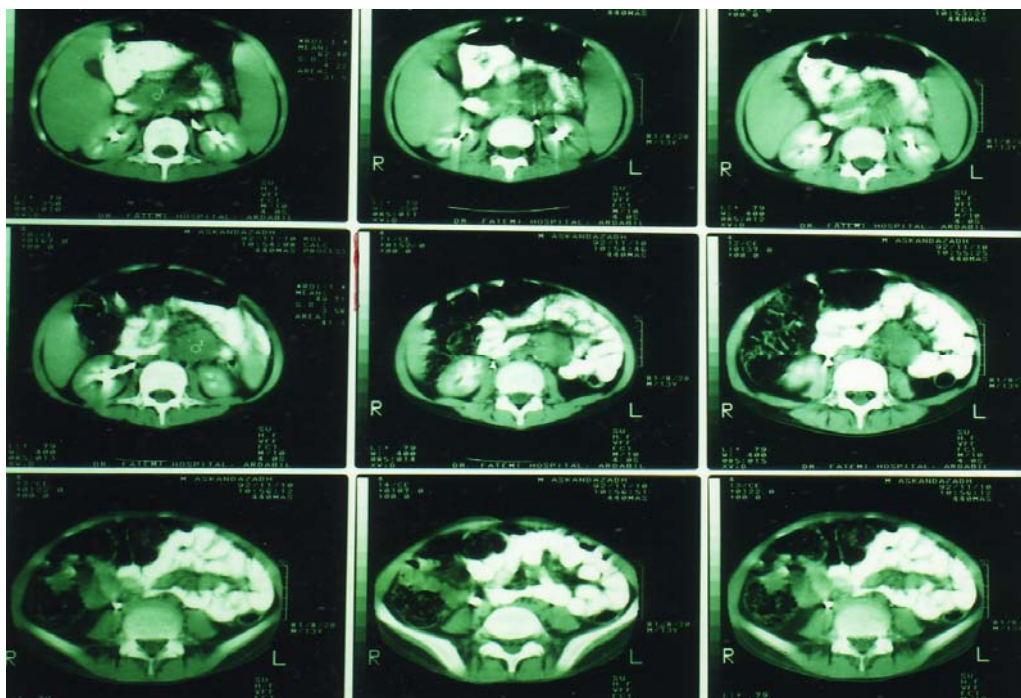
Contrast enhanced computed tomogram of patient, showing a lobular mass near abdominal aorta and L₃ vertebrae.
